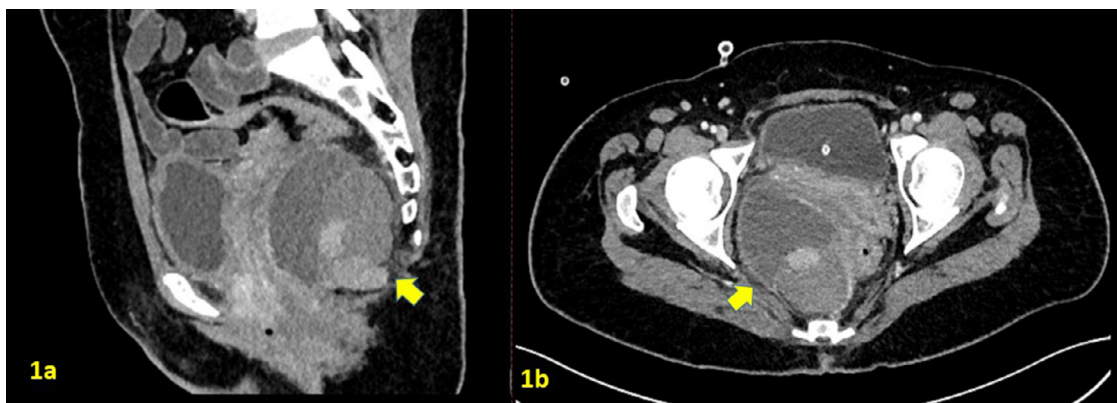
Contrast-enhanced CT-scan pelvis – (A) sagittal section showing multiloculated presacral cystic lesion (yellow arrow) abutting and displacing the cervix anteriorly, and (B) axial section showing displacement of rectal anteriorly and to the left.
